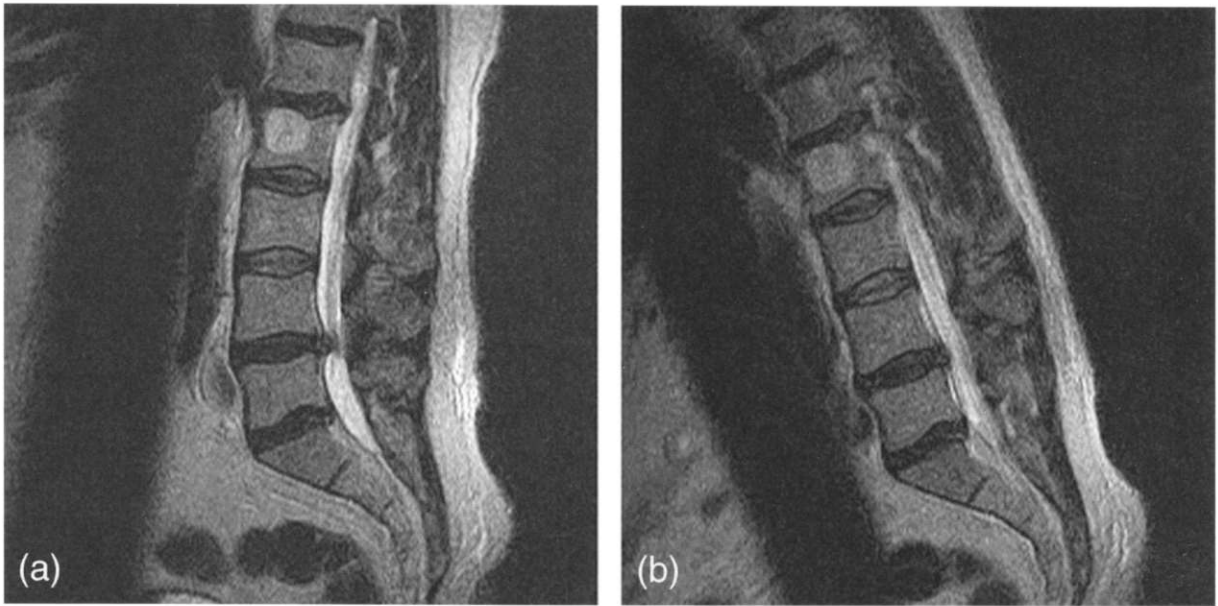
Reducing disc herniation. (a) Upright-neutral midline sagittal T2-weighted fast-spin echo MRI (pMRI) showing a focal midline posterior disc herniation at the L4–L5 level. (b) Upright-flexion midline sagittal T2-weighted fast-spin echo MRI (kMRI) revealing partial reduction of the posterior disc herniation at the L4–L5 level, as compared to the upright-neutral examination.
